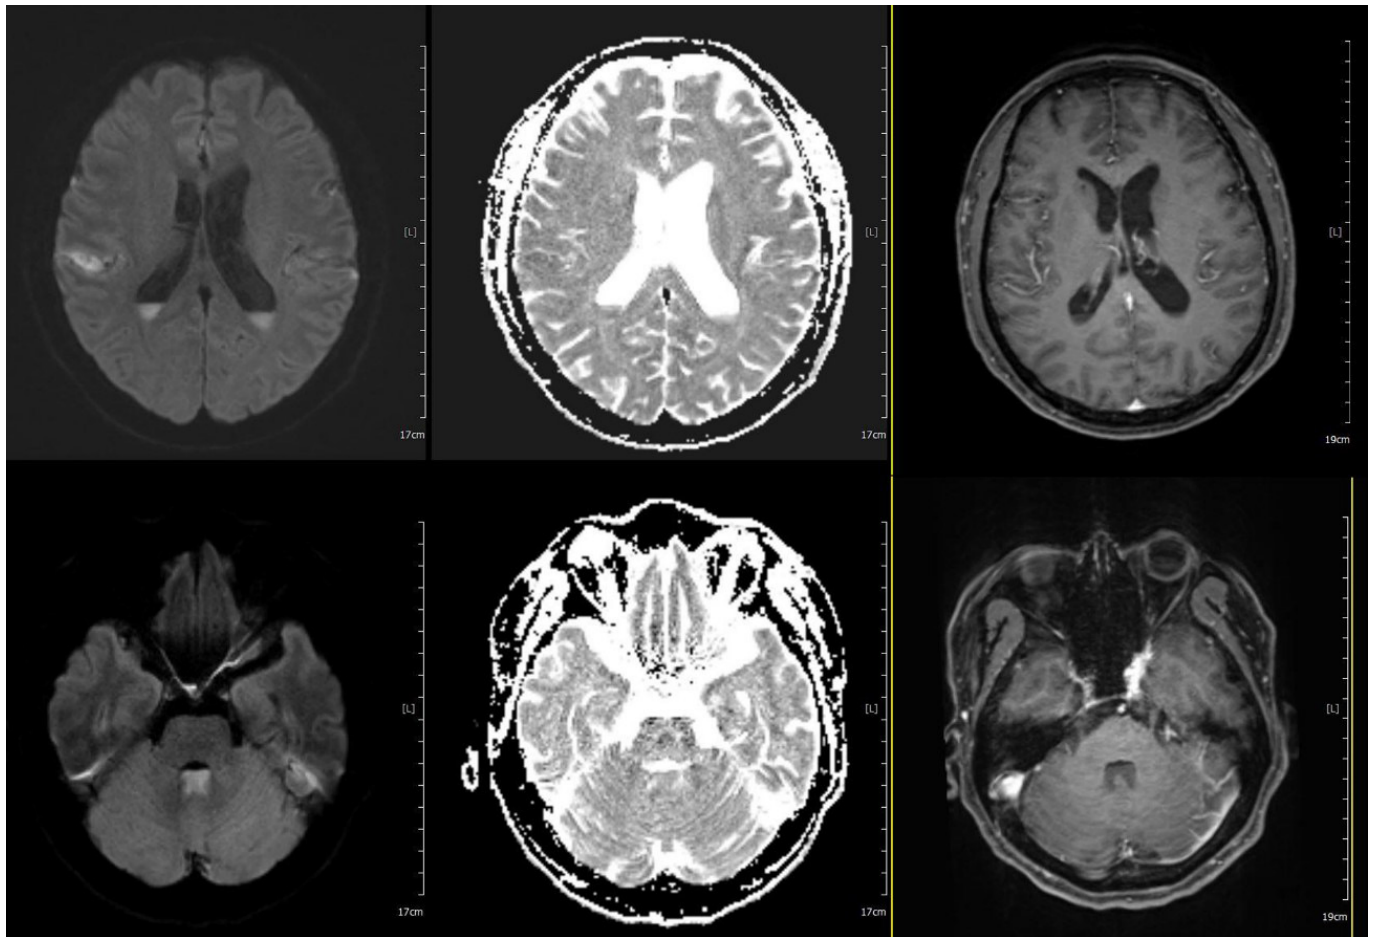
The first column of brain magnetic resonance imaging (MRI) shows hyperintense lesions in the bilateral fourth ventricles and bilateral frontoparietal cortical sulcus in diffusion-weighted imaging (DWI). The second column shows low apparent diffusion coefficient values in the corresponding lesions in DWI. The third column of T1-enhanced MRI shows no meningeal or ependymal enhancement.
